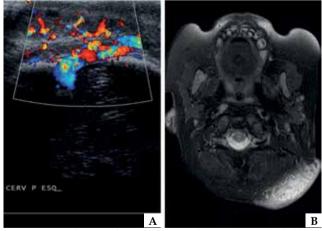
A - Ultrasound image showing heterogeneous high blood vessels; B - magnetic resonance imaging showing high intensity of the lesion on T2-weighted images
